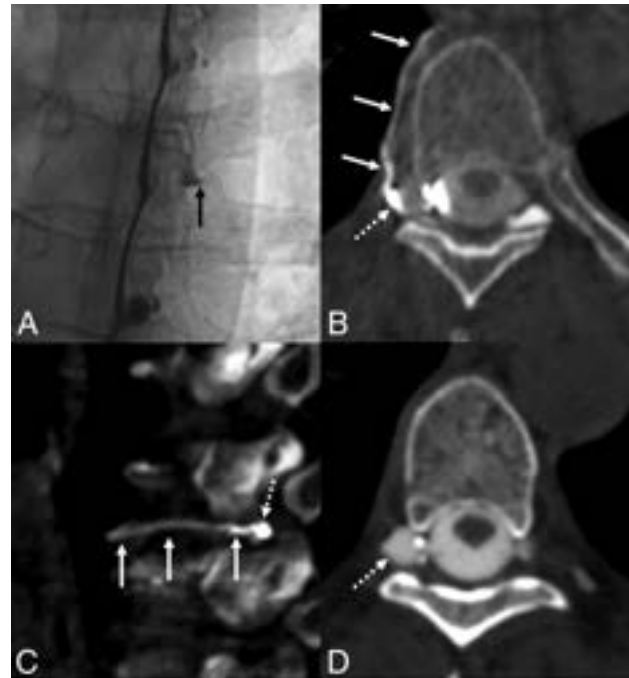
A 56-year-old woman with several months of orthostatic headaches. Brain MR imaging (not shown) demonstrated brain sag and pachymeningeal enhancement. Unsubtracted image from right lateral decubitus DSM (A) shows a prominent right T6 meningeal diverticulum (A, *arrow*), with subtle flickering density along the lateral edge of the diverticulum during dynamic imaging. Axial (B) and sagittal (C) images from CBCT obtained during contrast injection demonstrate opacification of the right T6 paraspinal vein (B and C, *solid arrows*), distinct from the diverticulum (B and C, *dashed arrows*), overall compatible with CSF-venous fistula. Axial 50-keV reconstruction from delayed right lateral decubitus CT obtained 15 minutes later (D) shows a prominent right T6 meningeal diverticulum (D, *dashed arrow*) without convincing venous contrast. Transvenous Onyx embolization of the right T6 fistula is pending.
